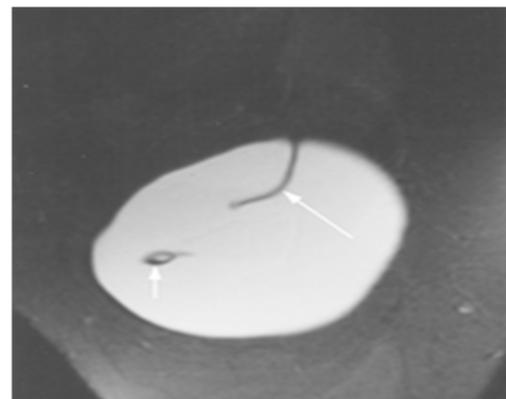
T2-weighted fast spin-echo silicone-suppressed MR image of saline-filled breast implant with a retention valve, showing a cross section through the proximal round neck of the valve (short arrow). A peripheral fold is also seen (long arrow) (Middleton and McNamara, 2000).
